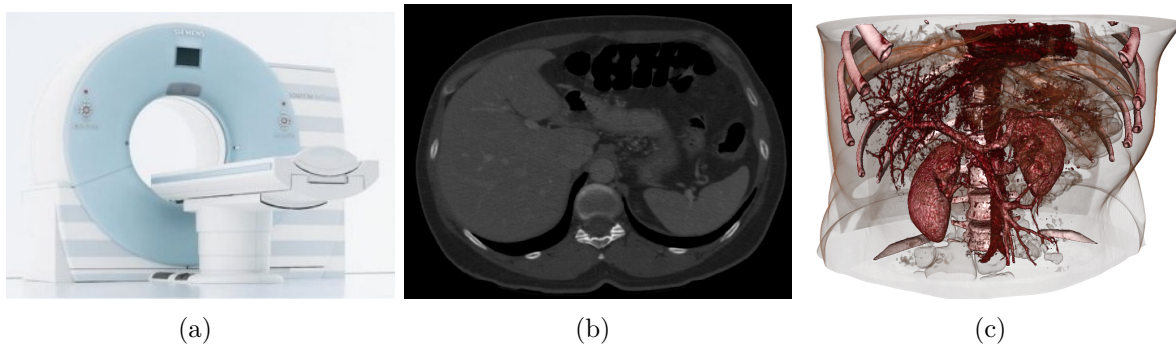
(a) Stationary CT scanner system (Siemens Somatom Definition, image courtesy of Siemens Healthcare) (b) 2D slice extracted from CT slice stack of liver CT scan. (c) 3D direct volume rendering of abdominal CTA data set, depicting kidneys, abdominal vasculature, bones and skin surface.
